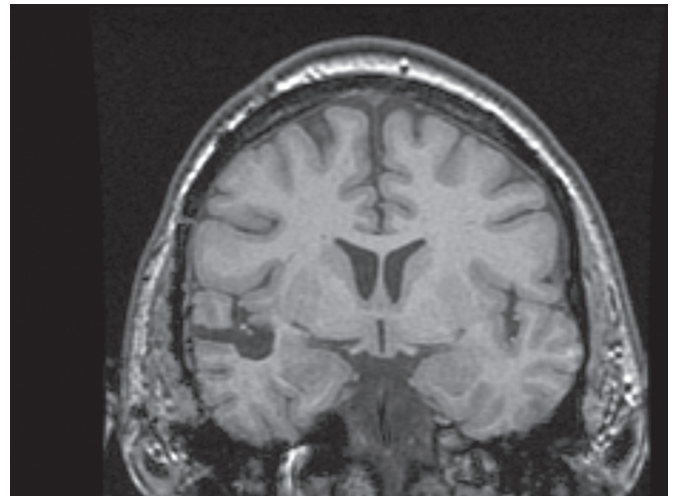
Oblique coronal plane, fluid attenuated inversion recovery sequence. MRI shows a left medial temporal lobe lesion. A lesionectomy and anterior temporal lobectomy was performed. The pathology revealed a dysembryoplastic neuroepithelial tumour. The patient continued to experience recurrent seizures after resection of the tumour. Note: the left side of the brain is on the right side of the figure.
